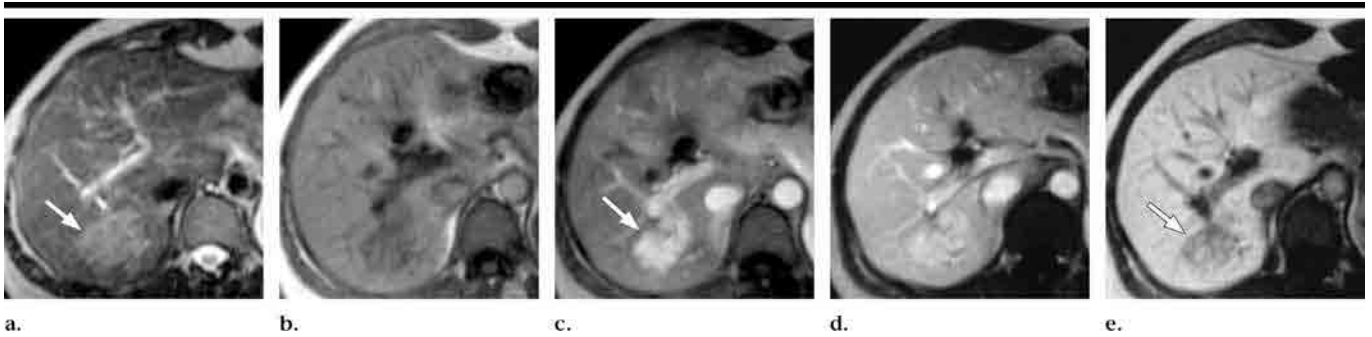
MR images in a 53-year-old asymptomatic woman with atypical FNH. (a) Transverse T2-weighted fast spin-echo (4000/108, 150° flip angle) image reveals a faintly hyperintense lesion (arrow) of approximately 7 cm in liver segment VI. (b) On unenhanced transverse T1-weighted GRE (160/4.7, 70° flip angle) image, the lesion is clearly hypointense to the surrounding parenchyma. (c) On corresponding postcontrast arterial phase T1-weighted GRE image, the lesion (arrow) demonstrates strong homogeneous enhancement and appears isointense and faintly hyperintense during subsequent (d) portal venous phase. No central scar is apparent, and accurate diagnosis is difficult on the basis of unenhanced and dynamic phase images alone. (e) On corresponding T1-weighted GRE image acquired 3 hours after injection of gadobenate dimeglumine, the lesion (arrow) has an atypical appearance with nodular areas of isointensity and slight hyperintensity interspersed with abundant internal hypointense septa, which results in the lesion appearing predominantly hypointense relative to the surrounding normal parenchyma. A characteristic central scar is not apparent and lesion biopsy is indicated.
